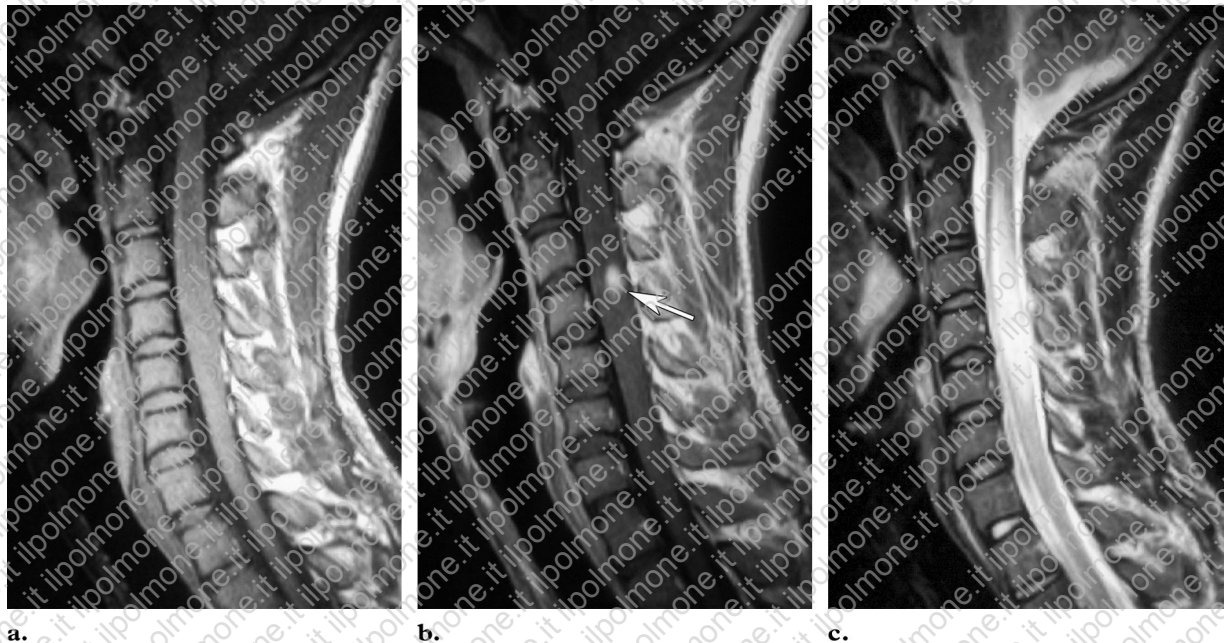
Spinal cord involvement in a 23-year-old man who presented with mild paresis of the hands. (a) T1-weighted MR image shows swelling of the cervical spinal cord. (b) Contrast-enhanced T1-weighted MR image depicts an enhancing intramedullary lesion (arrow), a finding that represents sarcoid granuloma. (c) T2-weighted MR image shows associated edema with markedly increased signal intensity.
